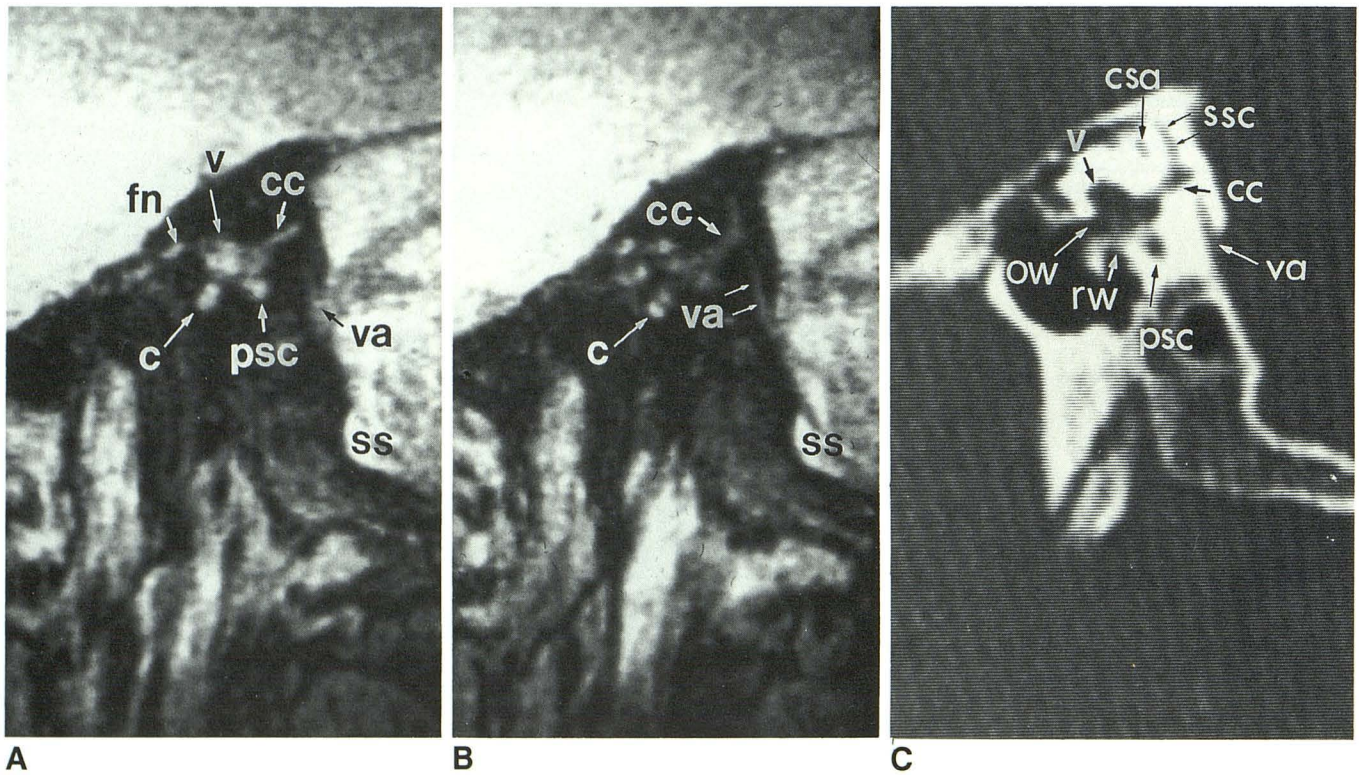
A, Sagittal 3DFT MR image at level of right vestibular aqueduct. Common crus (cc) arises from superior and posterior aspect of vestibule (v). Anterior to vestibule, a portion of facial nerve (fn) is seen in region of geniculate ganglion. Posteriorly, endolymphatic duct lies within vestibular aqueduct (va).
